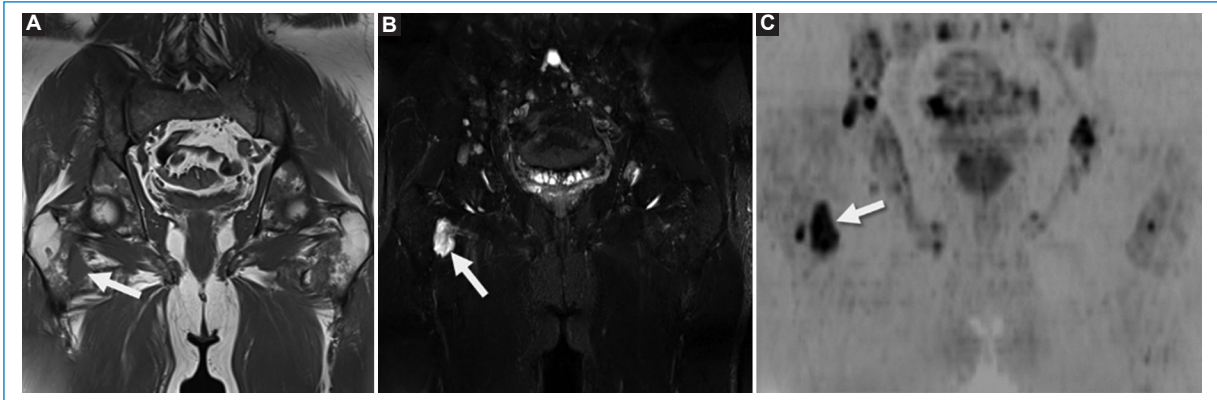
MRI of the pelvis, coronal T1 sequence (A) demonstrating multiple hypointense lesions, the dominant one in the lesser trochanter of the right femur, hyperintense on STIR (B), that restricts on diffusion (C) (arrows), compatible with foci of medullary infiltration.
